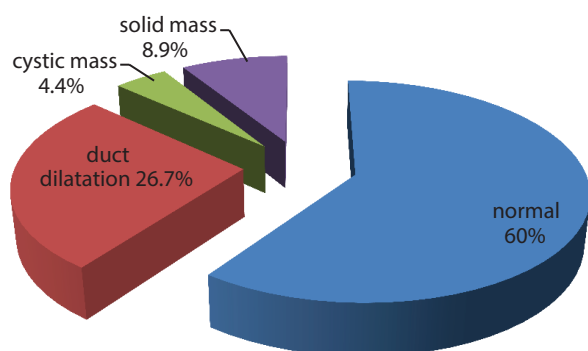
Ultrasound finding of women with breast pain.
